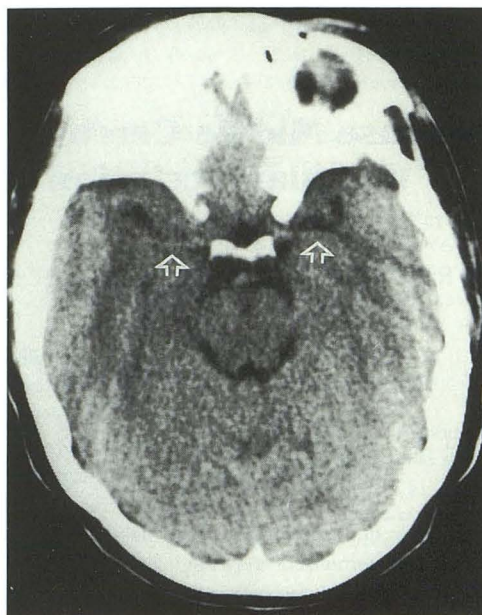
Patient 12. Noncontrast CT scan through the region of the circle of Willis. The M1 segment of each MCA is more dense than the adjacent brain (arrows).
